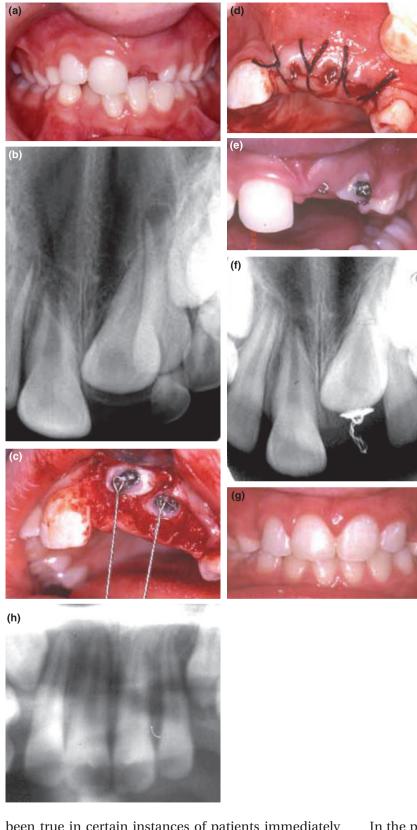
(a, b) Intra-oral clinical view and periapical radiograph showing unerupted left central and lateral incisors. The tiny mesiodens is not distinguishable on this view. (c, d) At surgery, only enough bone has been removed from the labial aspect of both teeth to permit bonding of an eyelet attachment and the surgical flap is fully sutured back. (e) No active traction was applied, yet 3 months later the lateral incisor erupted spontaneously. (f) Periapical view made 9 months postsurgery shows no movement of the central incisor and the regeneration of alveolar bone around its crown. (g, h) intra-oral and panoramic (anterior section only) radiographic view of the completed result after orthodontic traction was applied to the central incisor. Additional surgery was not undertaken.
